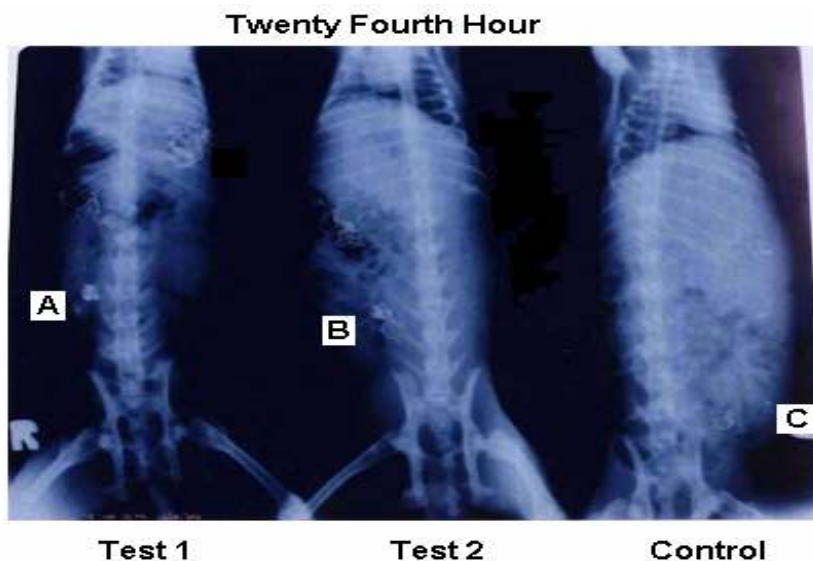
Soft X-ray photographs showing the sustaining effect of inlay tablets of metoprolol tartrate and hydrochlorothiazide
